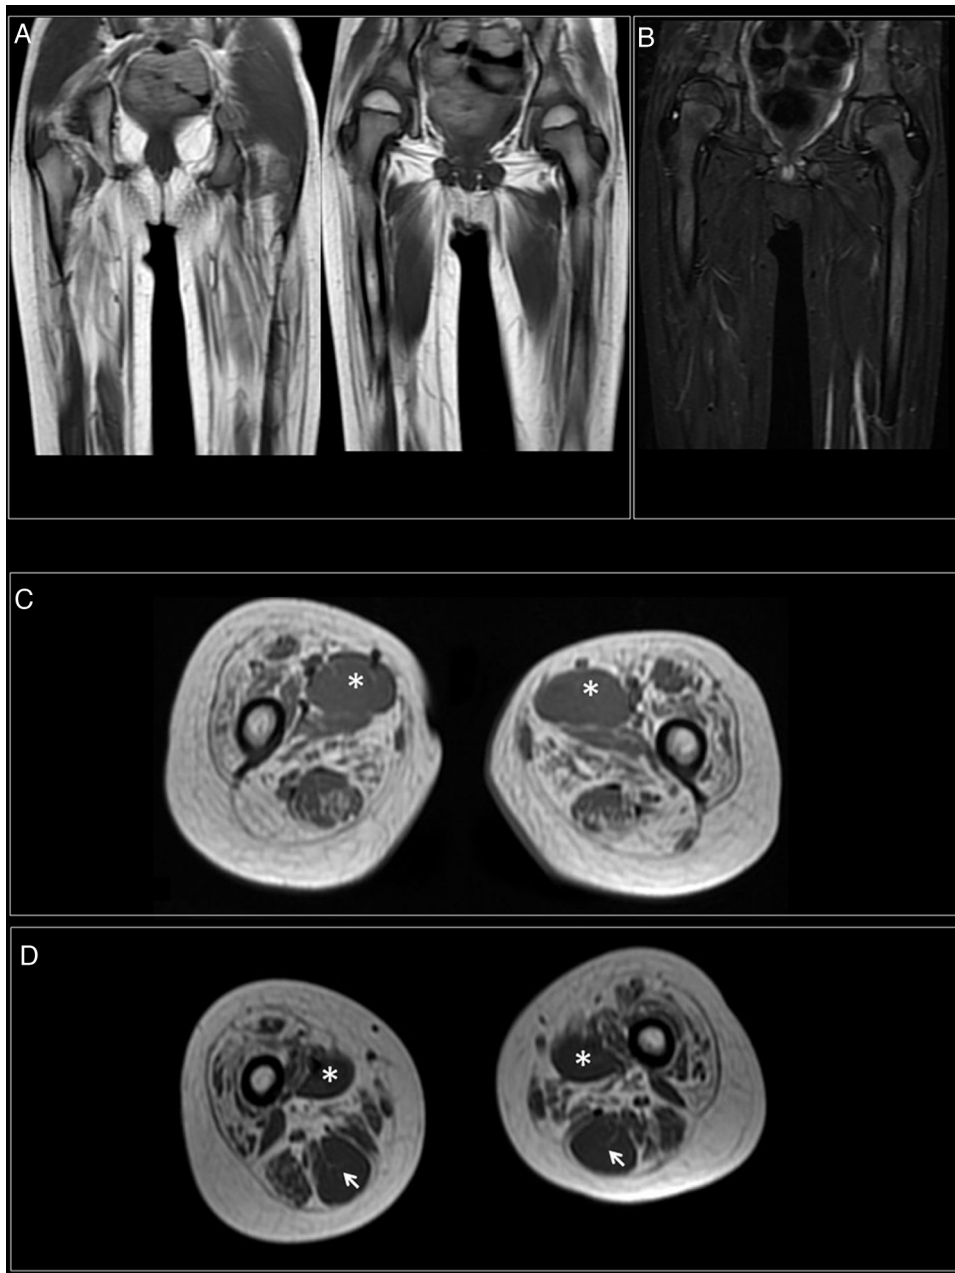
Muscle MRI. (A) Coronal T1-weighted sequence showing fatty replacement of the proximal muscles of both lower limbs; involvement is symmetrical and bilateral. (B) T2-weighted sequences showed no signs of acute denervation. (C) Symmetrical fatty replacement, with particular involvement of the anterior (quadriceps) and medial (adductor magnus) compartments. The adductor longus is preserved (asterisk). (D) Partial fatty replacement of the ischiotibial muscles in the posterior compartment, with the exception of the semitendinosus (arrow).
